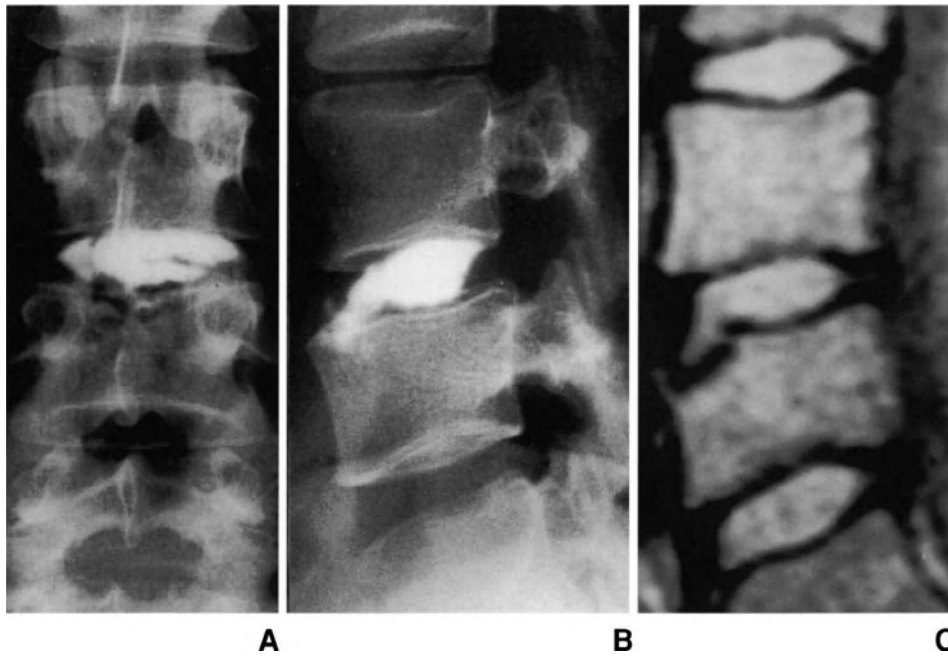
Anteroposterior (A) and lateral (B) discograms, and T2-weighted MR image (C) of 17-year-old patient with an anterior marginal intravertebral herniation of L4 disc. The patient first complained of low back pain after vertebral trauma in flexion-compression. Penetration of contrast medium and of nucleus pulposus into the anterior portion of the vertebral body of L4 is visible on the lateral discogram and MR image, respectively.
